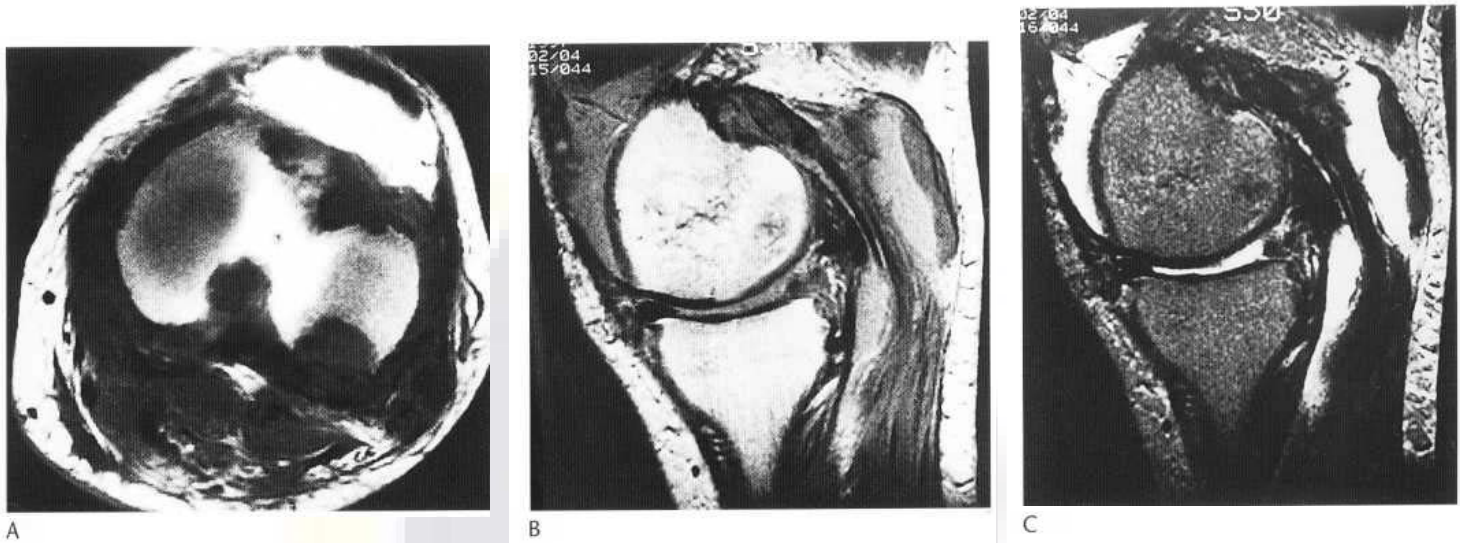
Dialysis-related amyloidosis of the knee. Axial T_1 -weighted (A), sagittal proton density (B) and T_2 -weighted (C) MR images showing numerous erosions of the margin of the tibia and characteristic low-signal-intensity masses within the synovium, most evident posteriorly within the popliteal cyst. A large joint effusion is also present.
